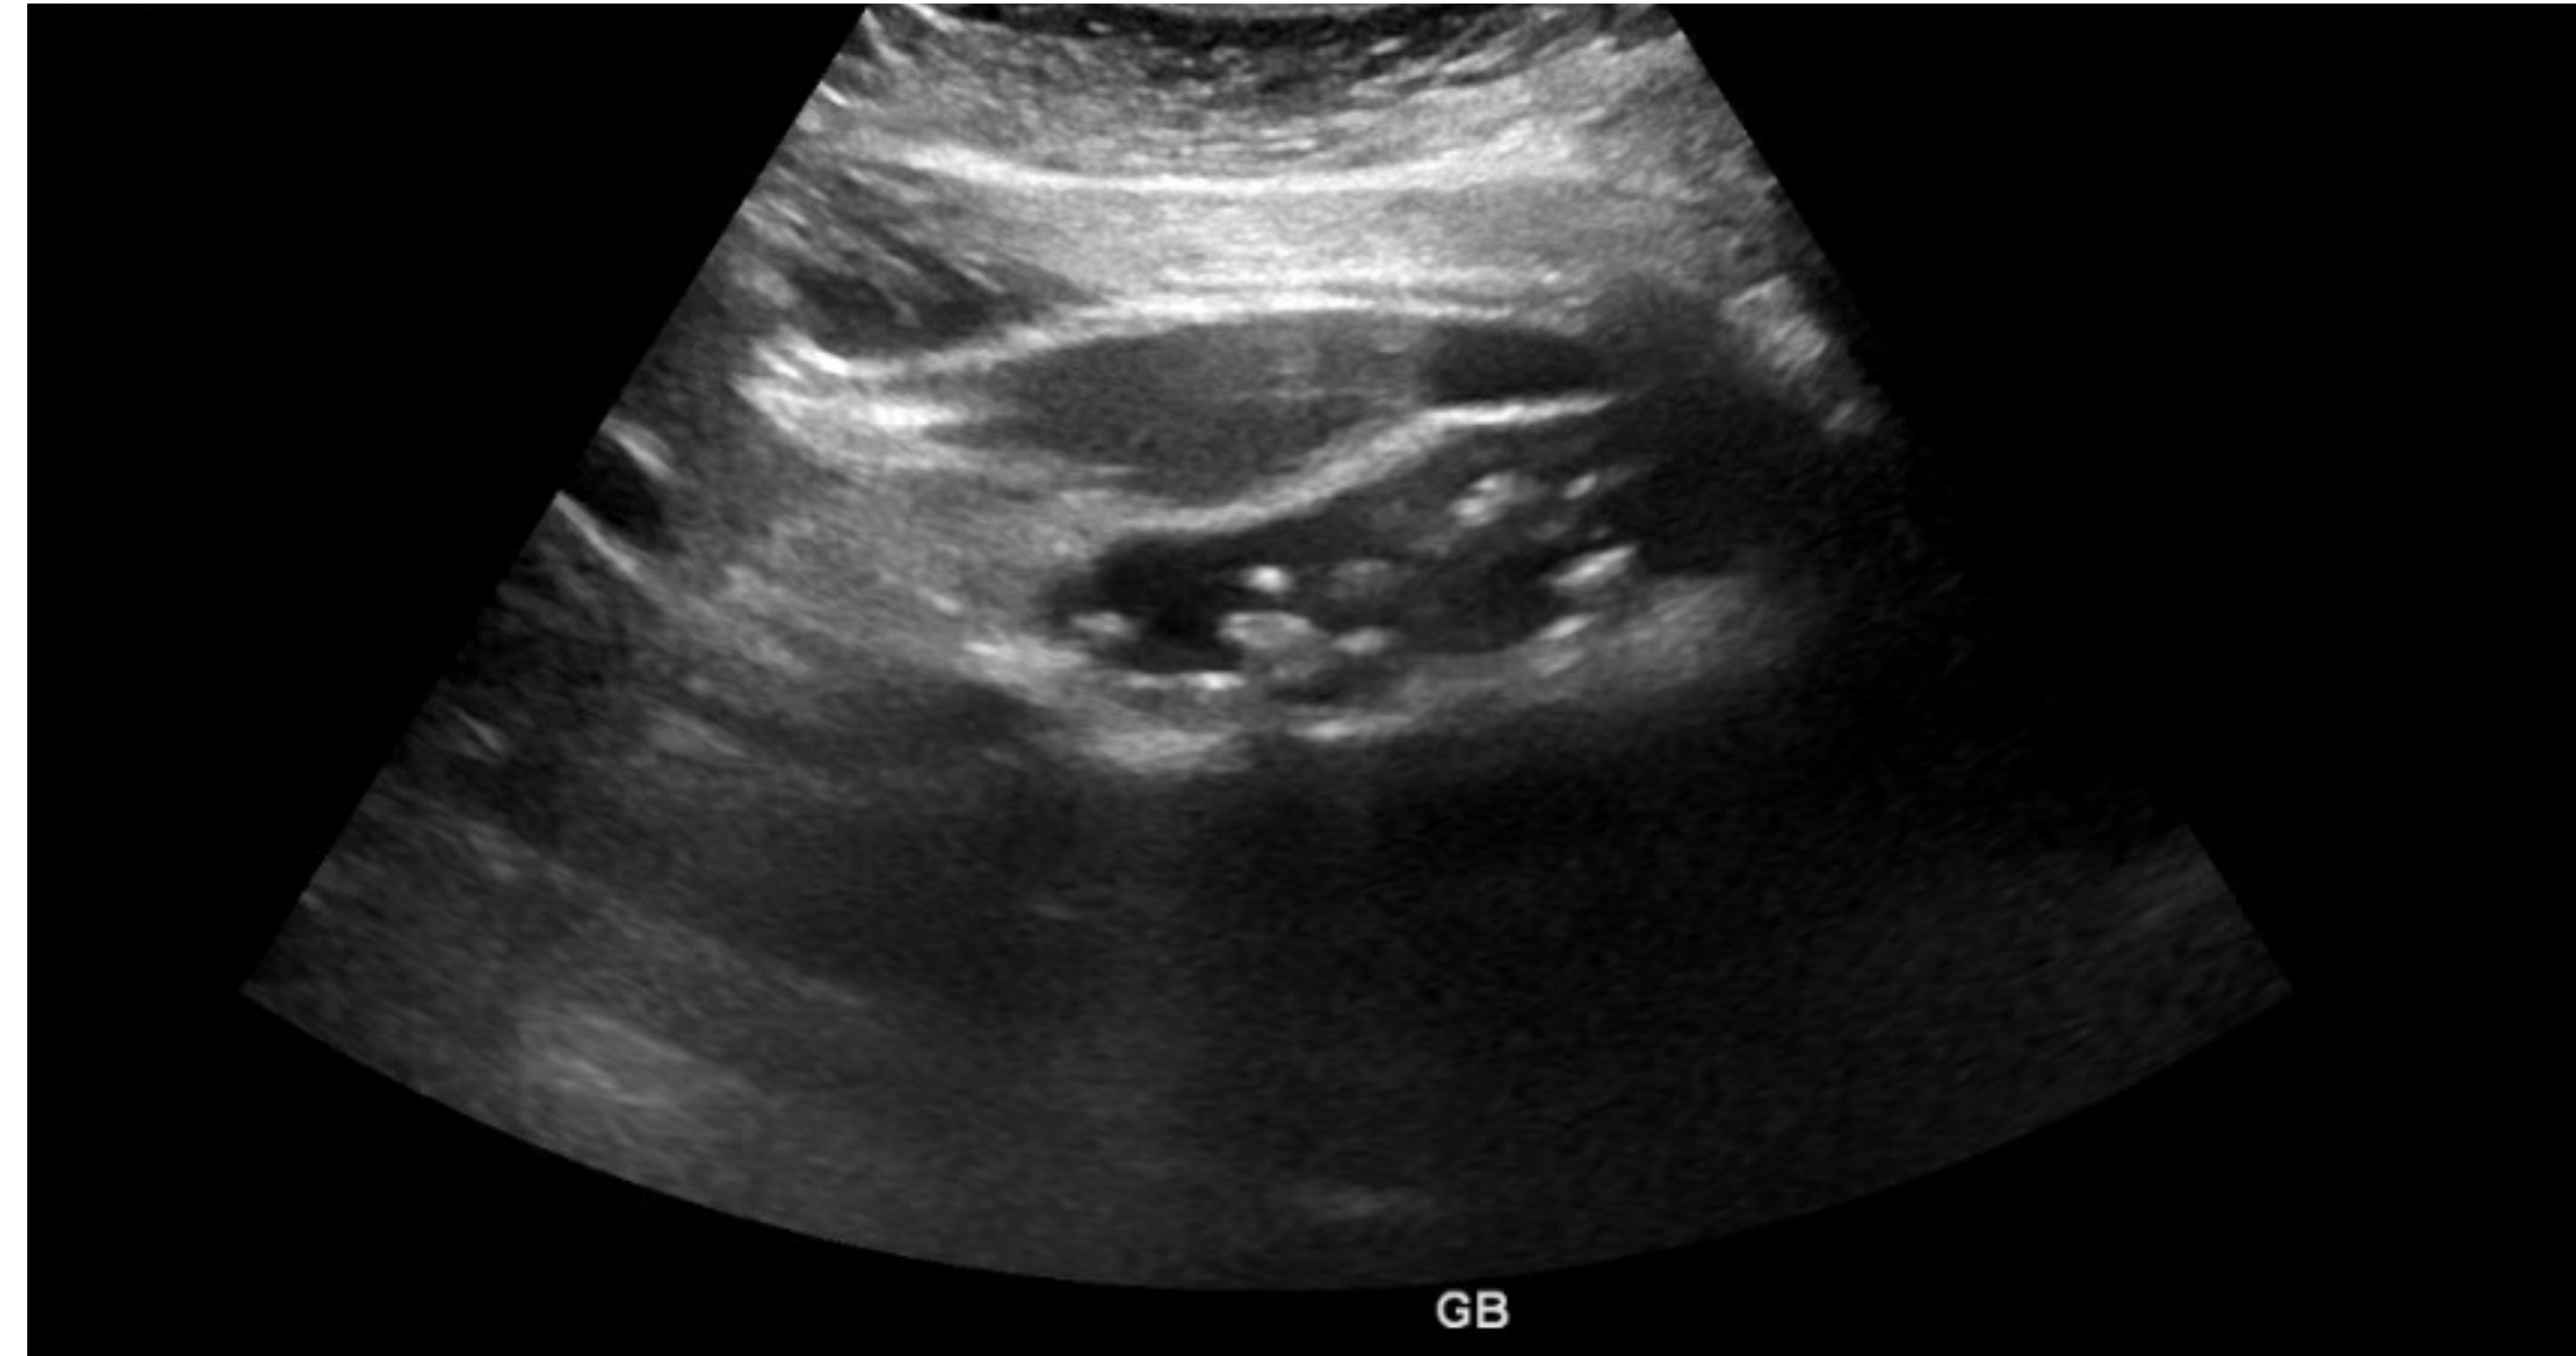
Left upper quadrant ultrasound showing calculi in the gallbladder
